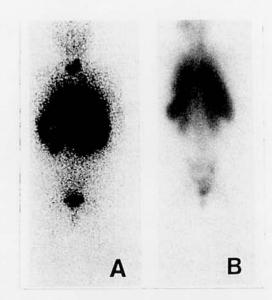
Regression of AA amyloidosis. Serial posterior whole body ¹²³I-SAP scintigraphs of a young woman with JRA complicated by AA amyloidosis. Scans at presentation with nephrotic syndrome (A) show intense uptake of labelled SAP into extensive amyloid deposits in the liver, spleen, kidneys and thyroid gland. Treatment with chlorambucil induced a complete remission of inflammatory disease activity and was followed by the disappearance of proteinuria; repeat SAP scan 3 years later (B) indicates substantial regression of amyloid with only minor splenic adrenal deposits remaining. The remainder of the image is blood pool background which is increased when specific uptake into amyloid is reduced, and radioactive breakdown products in the bladder.
